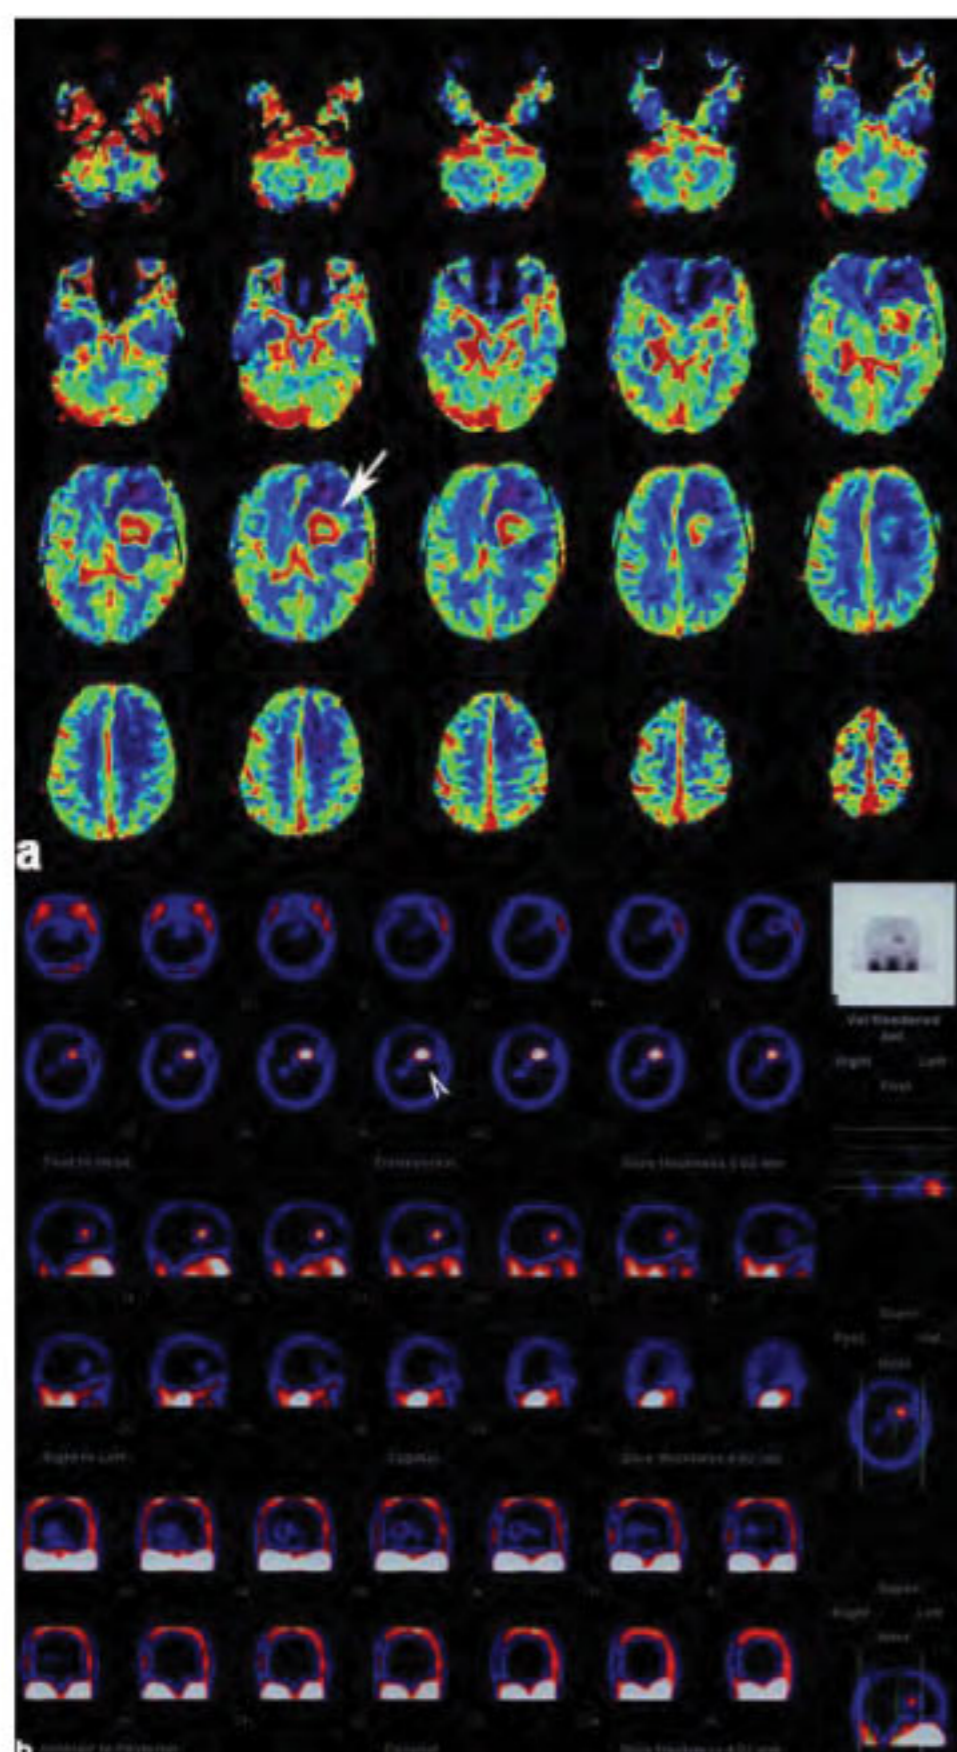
A 45 years old woman with glioblastoma multiforme. The lesion displays: a) elevated relative cerebral blood volume (rCBV) on colored CBV map (arrow) and b) intense ^{99m}Tc -tetrofosmin uptake on SPET scintigraphy (arrowhead). The tracer UI obtained was 42.9.
